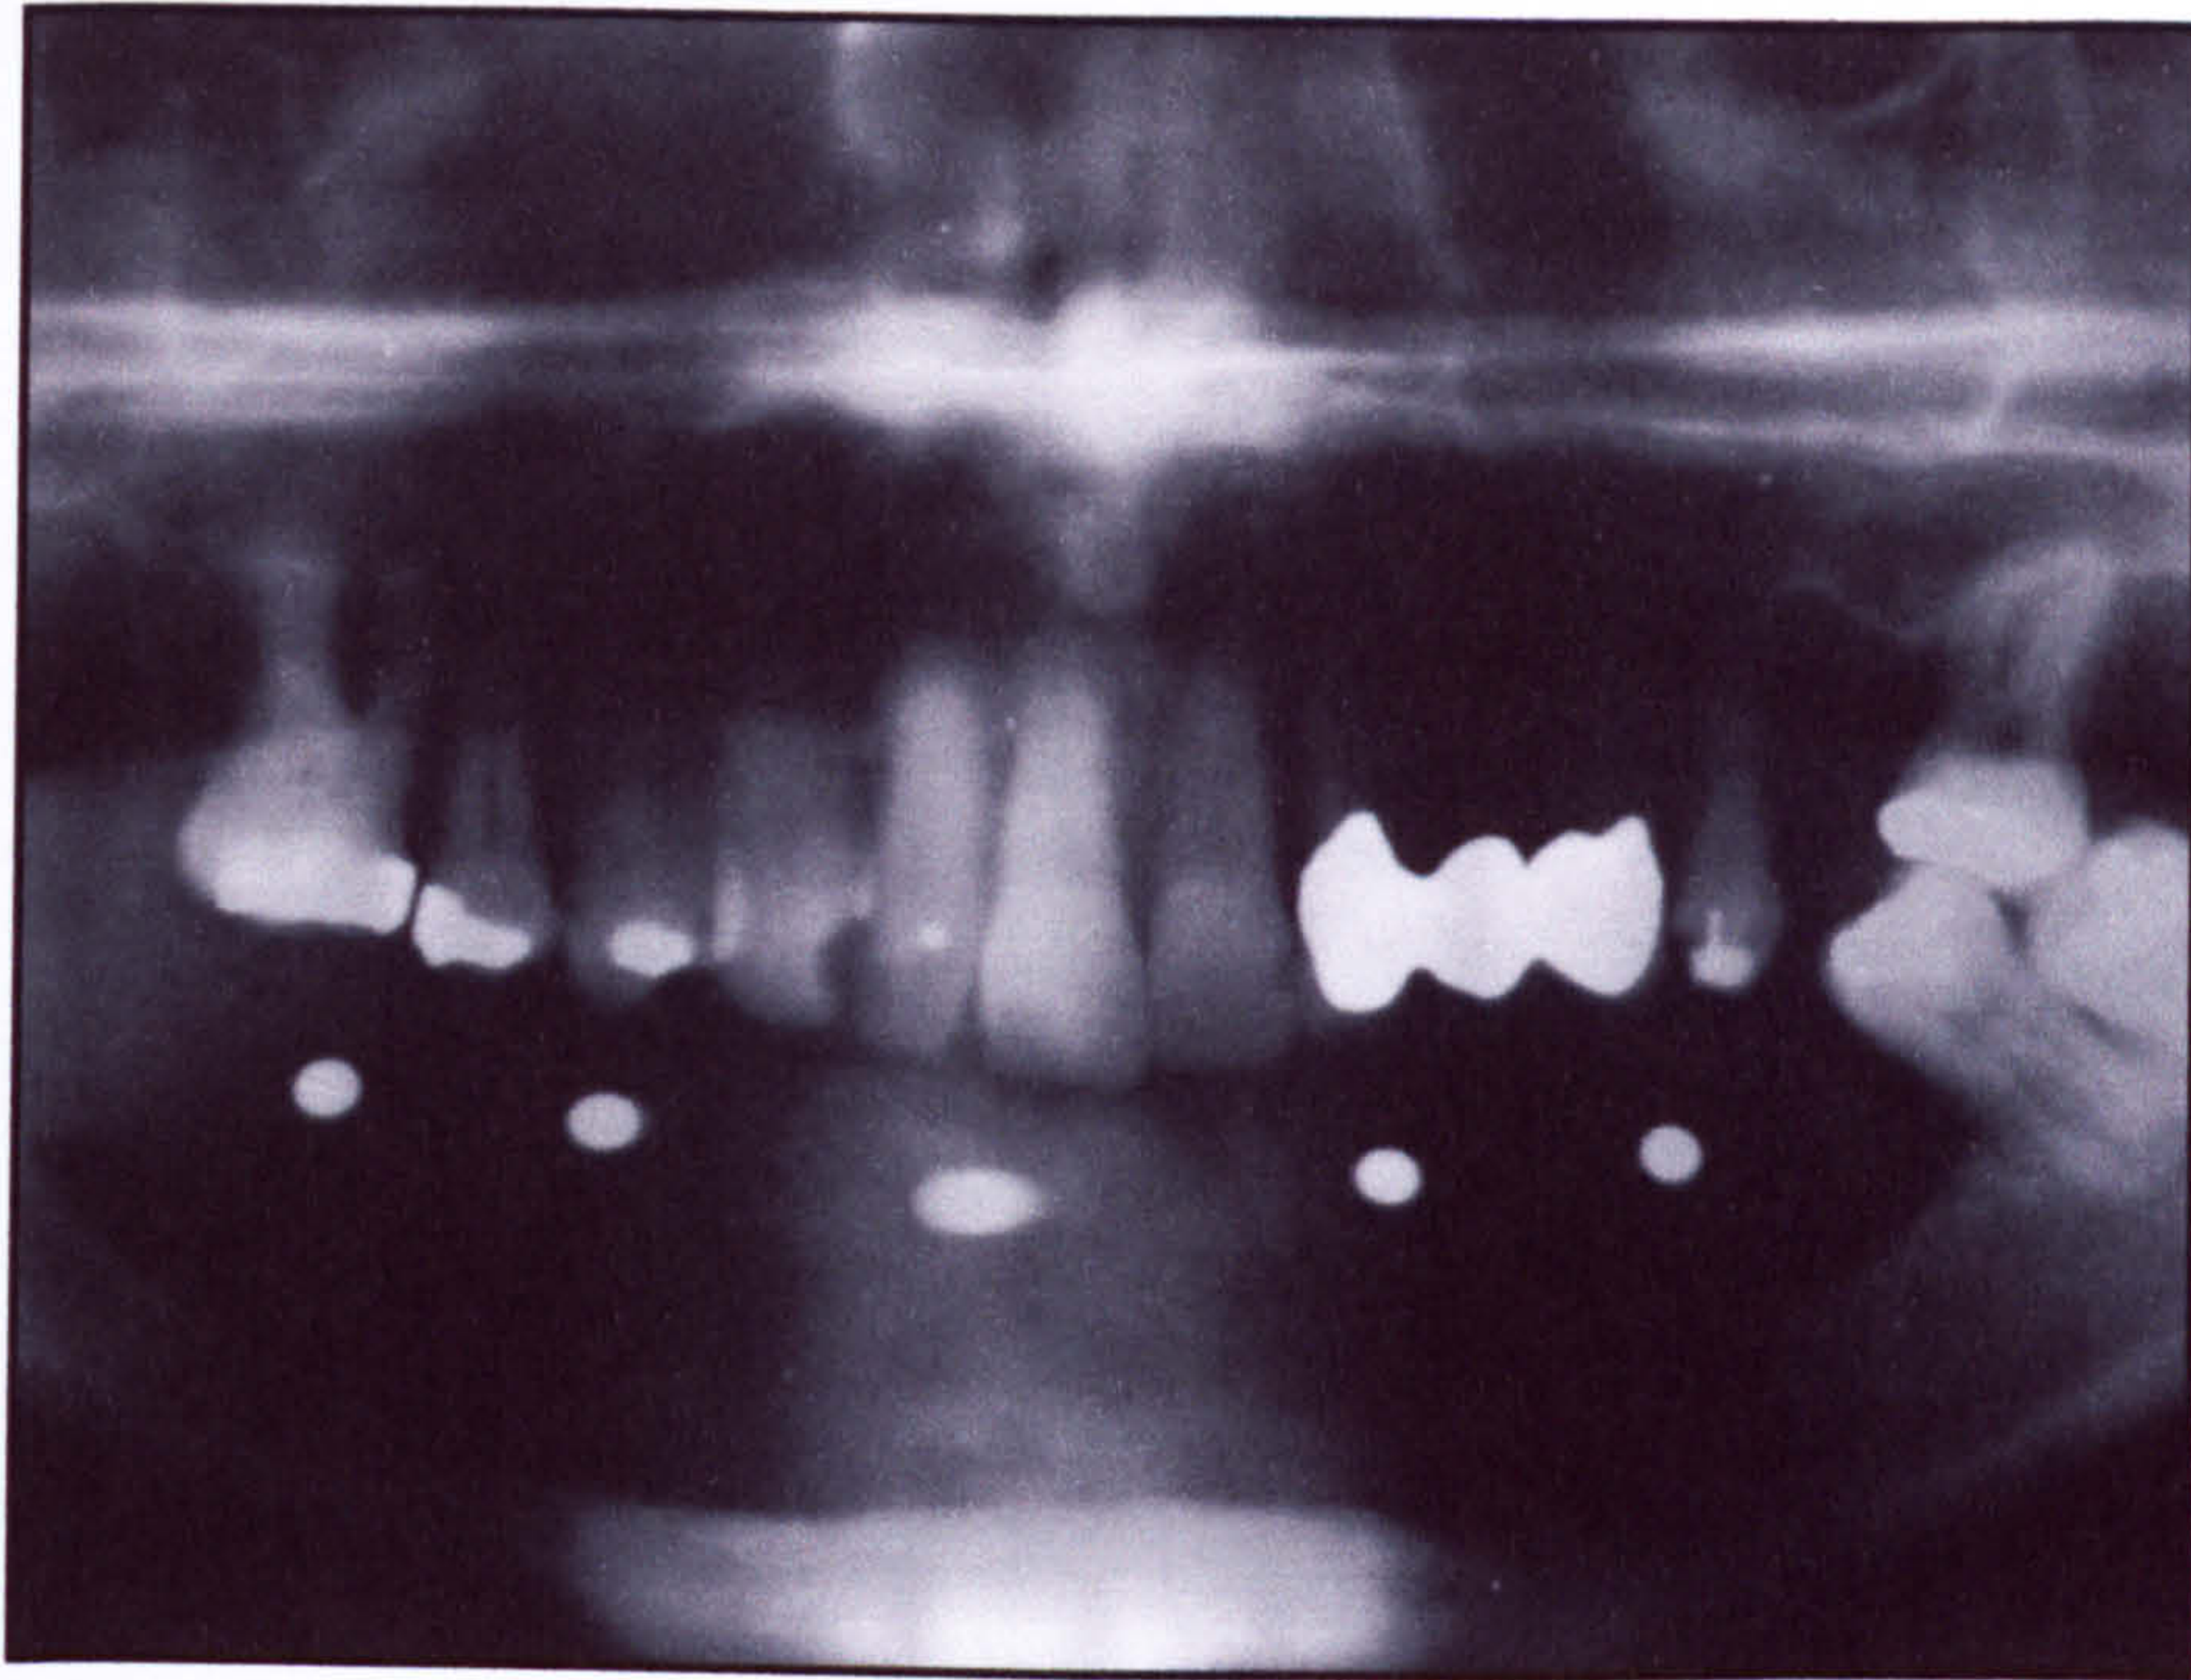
DPT radiographic view used for bone quantity assessment.
